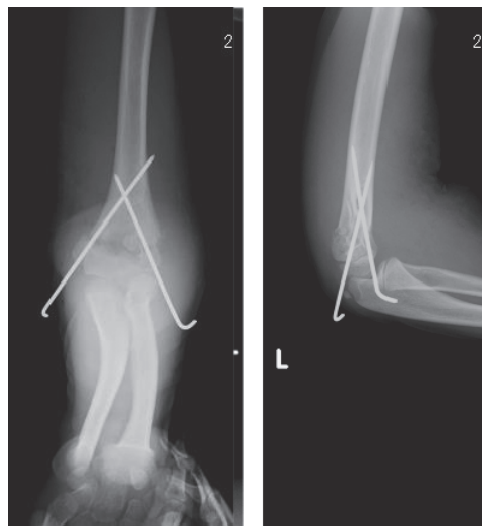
Plain X-ray findings after the first surgery
